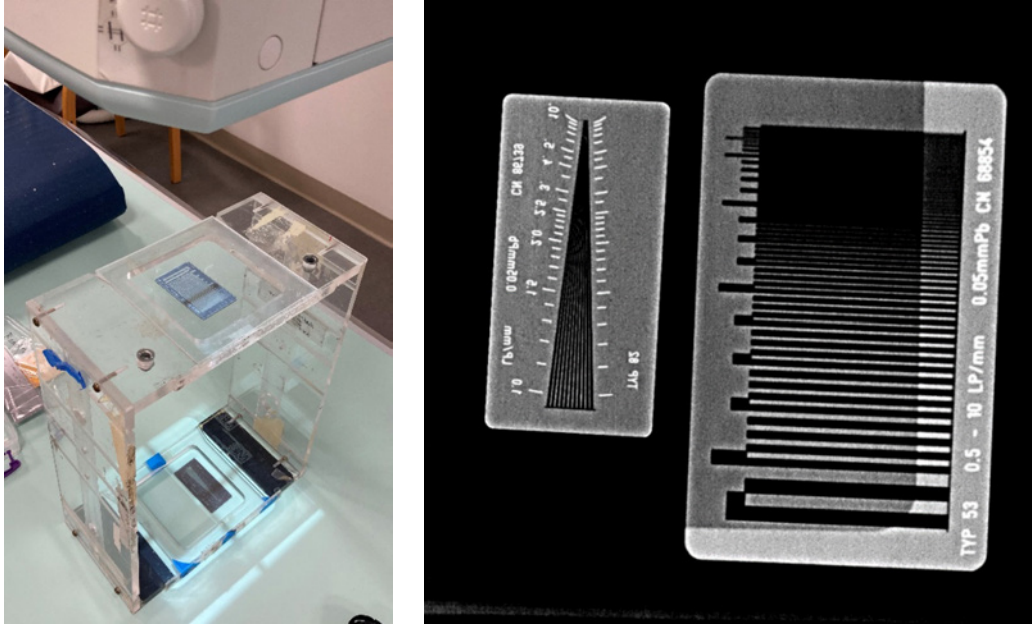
Measuring both focal spot location and image plane location. Left: setup with two objects at different magnification imaged simultaneously. Right: radiograph of objects.
